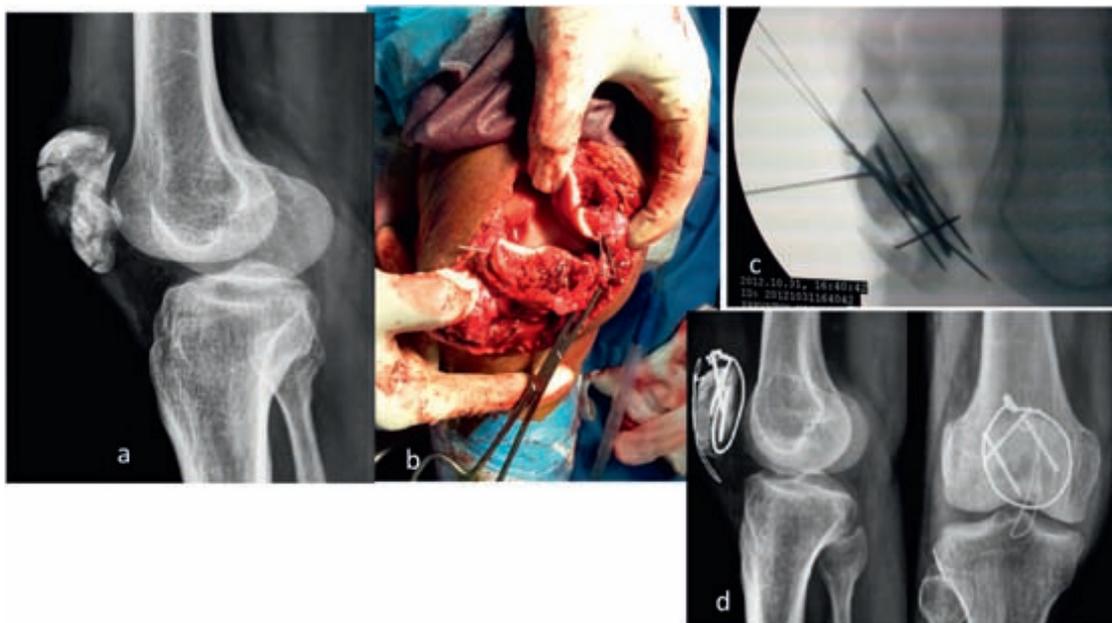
(a) Preoperative X-ray with OTA 34-C3 comminuted fracture. (b) Intraoperative reduction and temporary fixation with 1.2 mm k-wire for upper major fragment and lower major fragment. (c) Intraoperative fluoroscopy to confirm articular reconstruction. (d) 24-months follow X-ray of the same patient.
